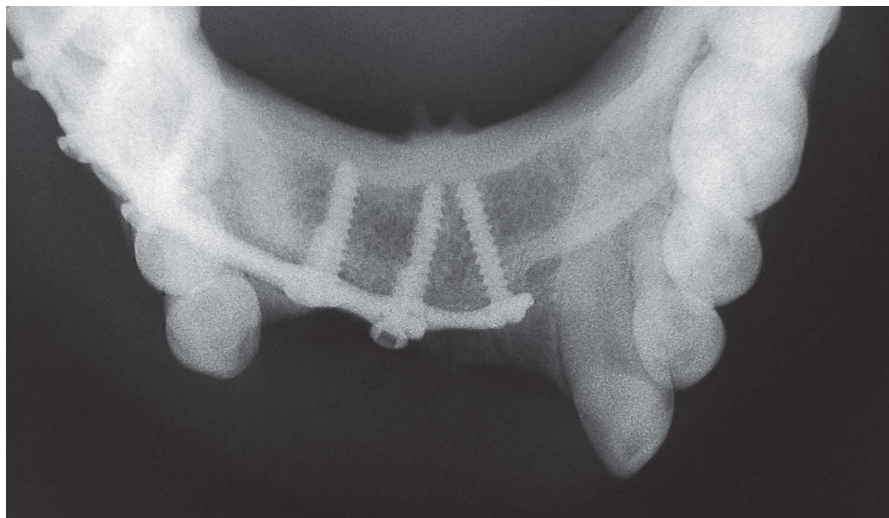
Initial radiograph.
